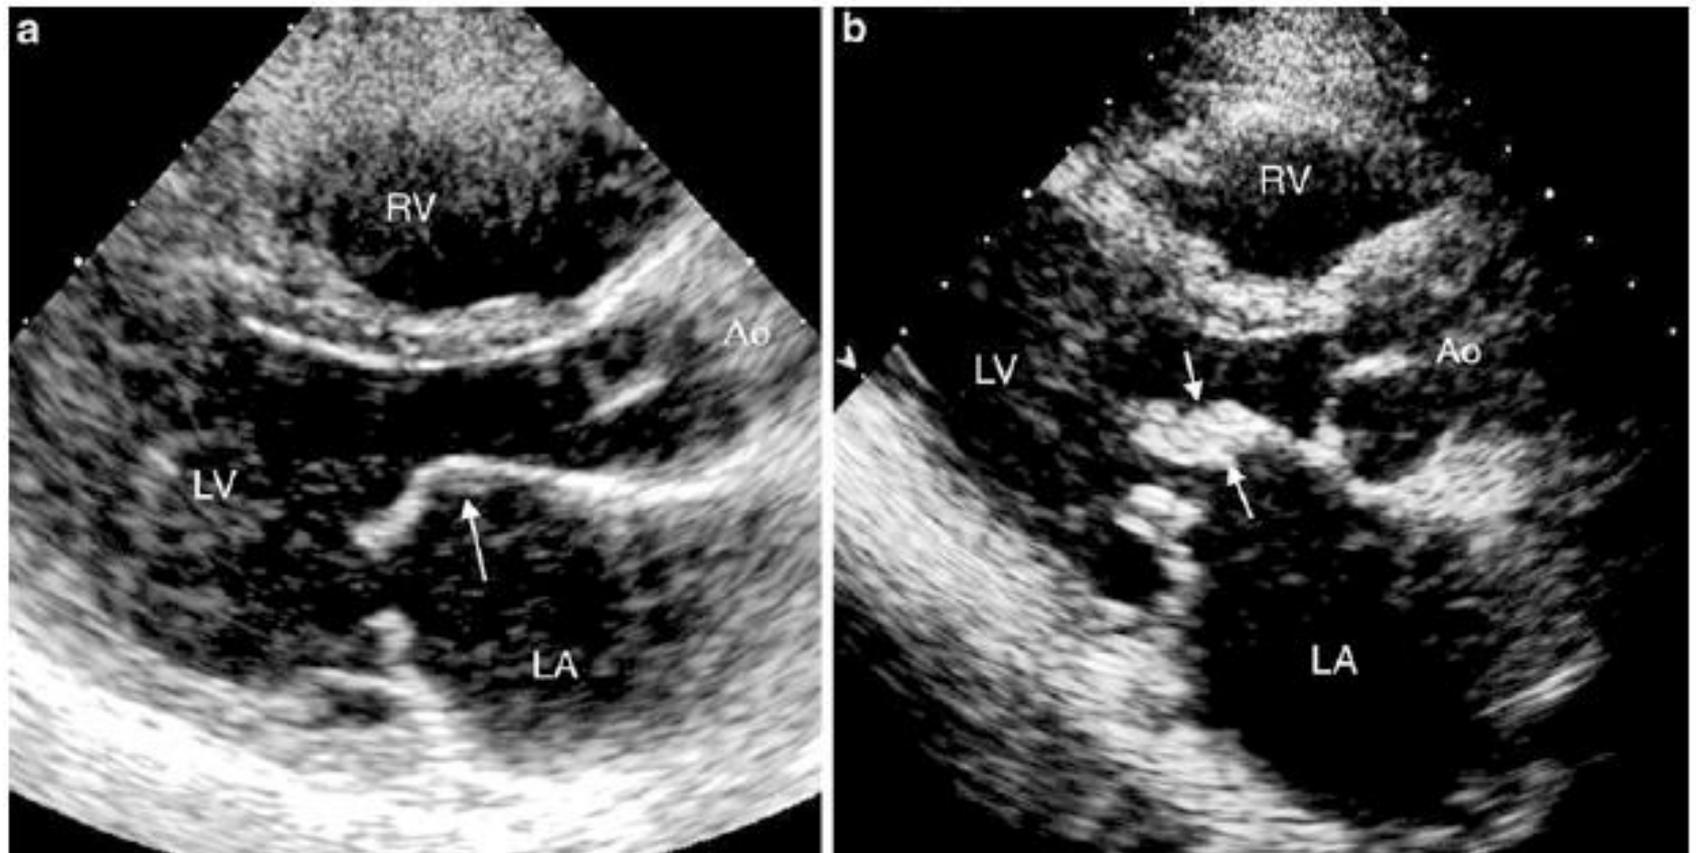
a Two-dimensional image in the parasternal long-axis view of a young patient with mitral stenosis. In this case the body of the anterior leaflet is flexible and elastic and this leads to the diastolic doming characteristic (*arrow*).
